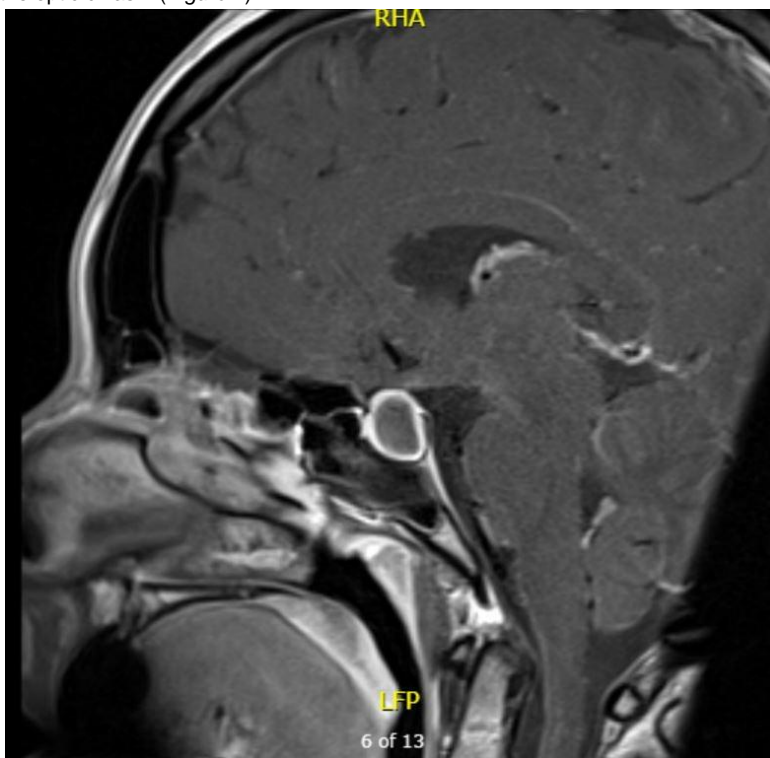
A Gadolinium enhanced MRI brain reveals a rim enhancing pituitary lesion measuring 12.8 x 21 x 14mm.
